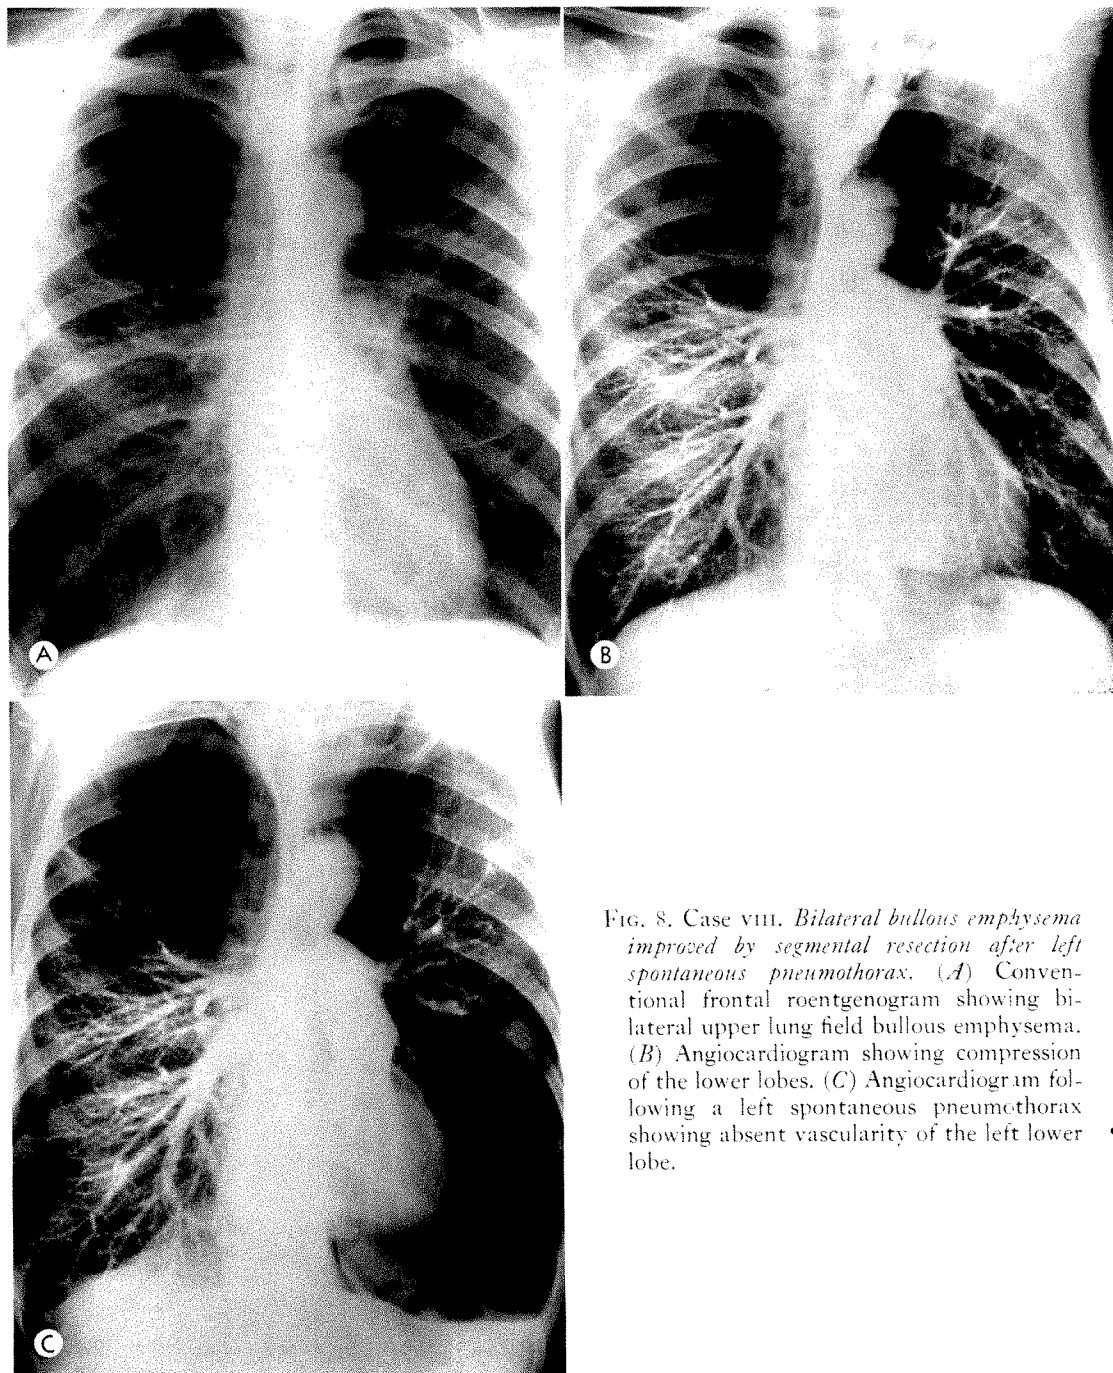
Case VIII. *Bilateral bullous emphysema improved by segmental resection after left spontaneous pneumothorax.* (A) Conventional frontal roentgenogram showing bilateral upper lung field bullous emphysema. (B) Angiogram showing compression of the lower lobes. (C) Angiogram following a left spontaneous pneumothorax showing absent vascularity of the left lower lobe.
